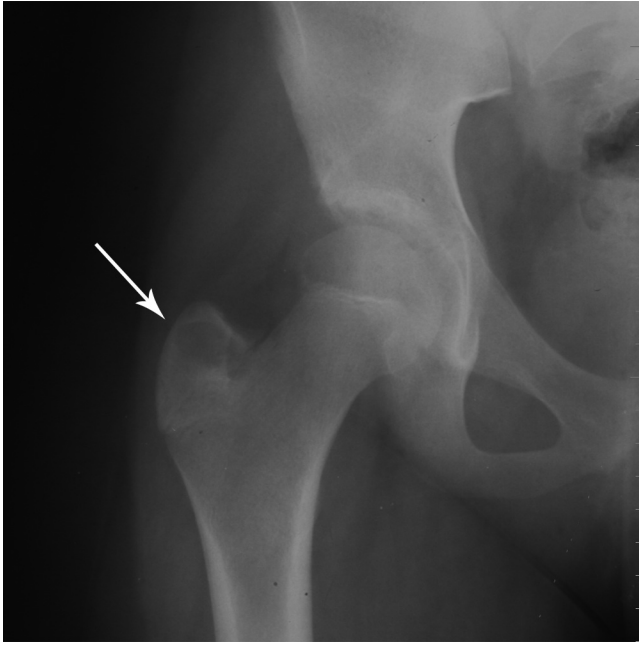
10-year-old girl with recurrence of chondroblastoma. Right hip radiograph. Frontal view of the right hip reveals a well-circumscribed lytic lesion (arrow) in the greater trochanter.
